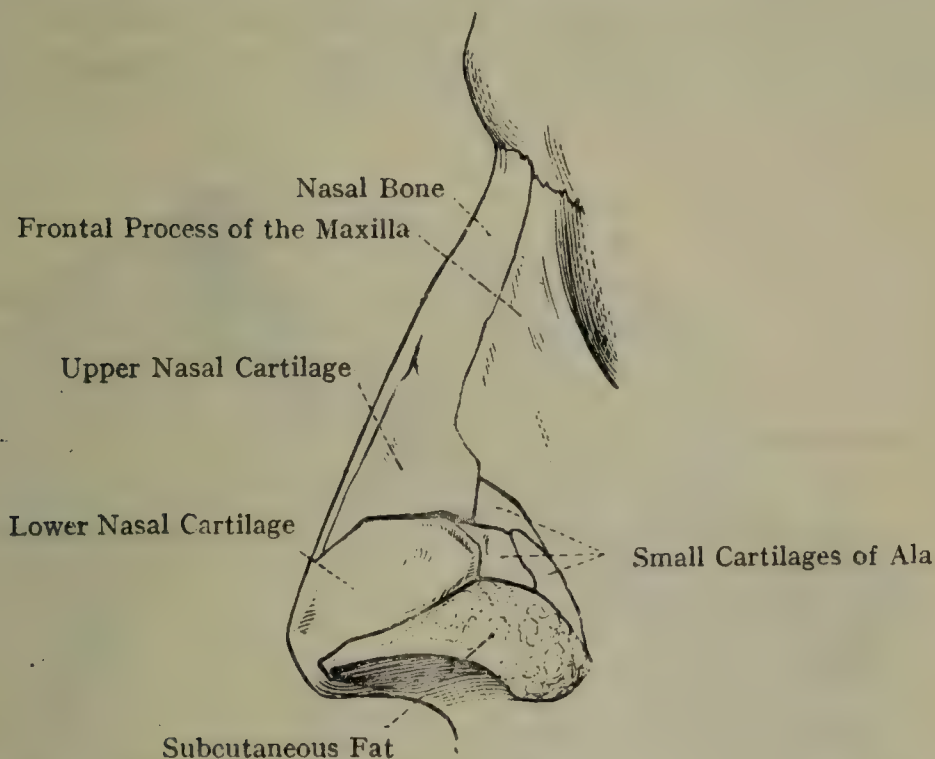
THE CARTILAGES OF THE NOSE (LATERAL ASPECT) (ARNOLD).
